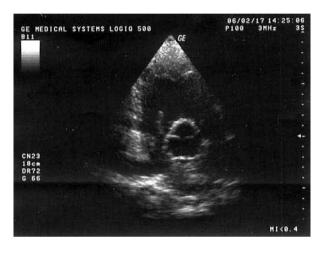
Transthoracic echocardiographic examination. Short axis view. A mobile structure in the right atrium protruding into the right ventricle in diastole.
